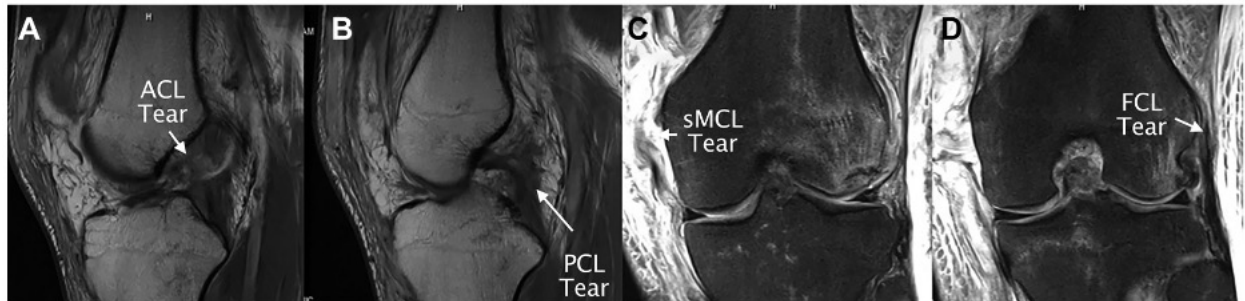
Preoperative T2-weighted magnetic resonance imaging (MRI) series of the left knee in a single patient. An ACL tear (A) and a PCL tear (B) are observed in the sagittal plane. A proximal sMCL tear (C) and a FCL tear (D) are also present in the coronal plane. ACL, anterior cruciate ligament; PCL, posterior cruciate ligament; sMCL, superficial medial collateral ligament; FCL, fibular collateral ligament.<sup>9</sup>
